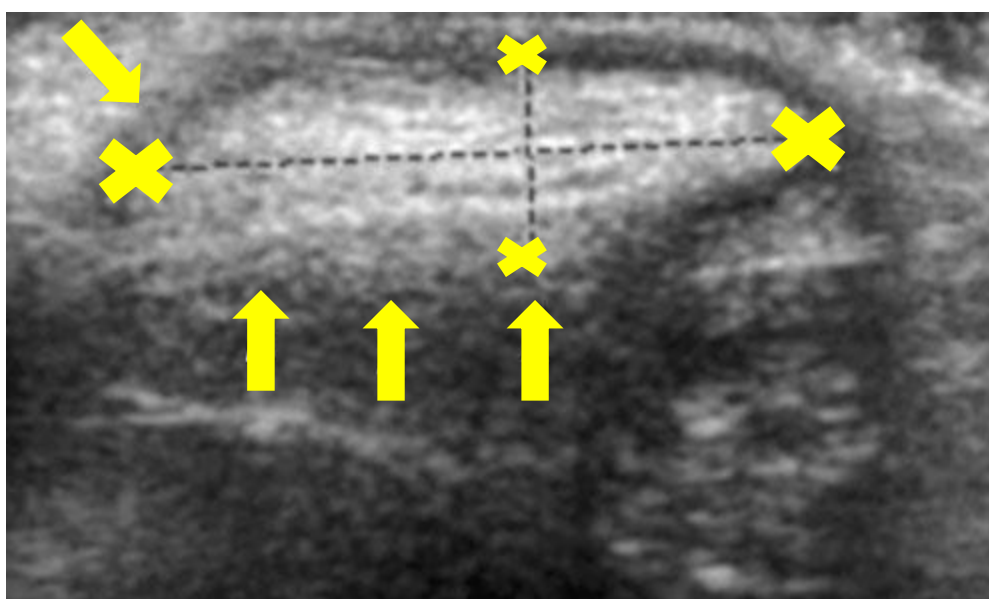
The appearance of a tophi under ultrasound imaging. From Ultrasound features of tophi in chronic tophaceous gout, de Ávila Fernandes (129). Reprinted with permission.
